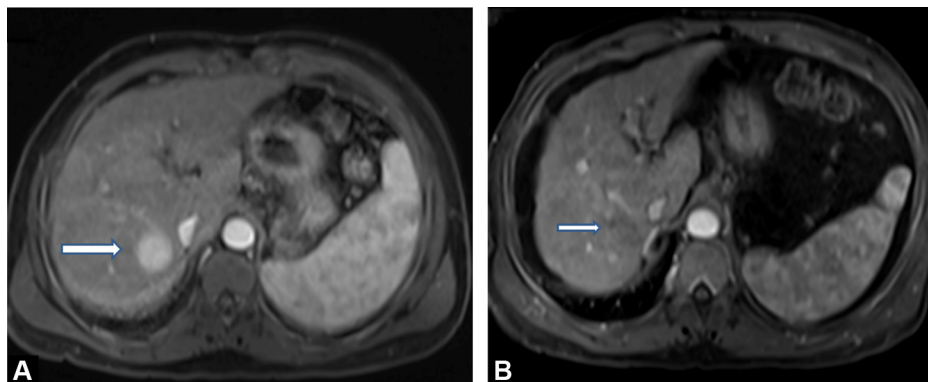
55-year-old man with hepatitis B-related cirrhosis and hepatocellular carcinoma (HCC) in segment 7 of the liver: A: MR image of the liver in the axial plane obtained during the arterial phase following intravenous administration of gadolinium chelate shows a well-defined, 2.5 cm, homogenous, hypervascular HCC nodule in segment 7 of the liver (arrow). The patient was treated using radiofrequency ablation (RFA); B: four weeks after RFA, MR image of the liver in the axial plane obtained during the arterial phase shows lack of enhancement within the tumor site (arrow) consistent with complete response.
